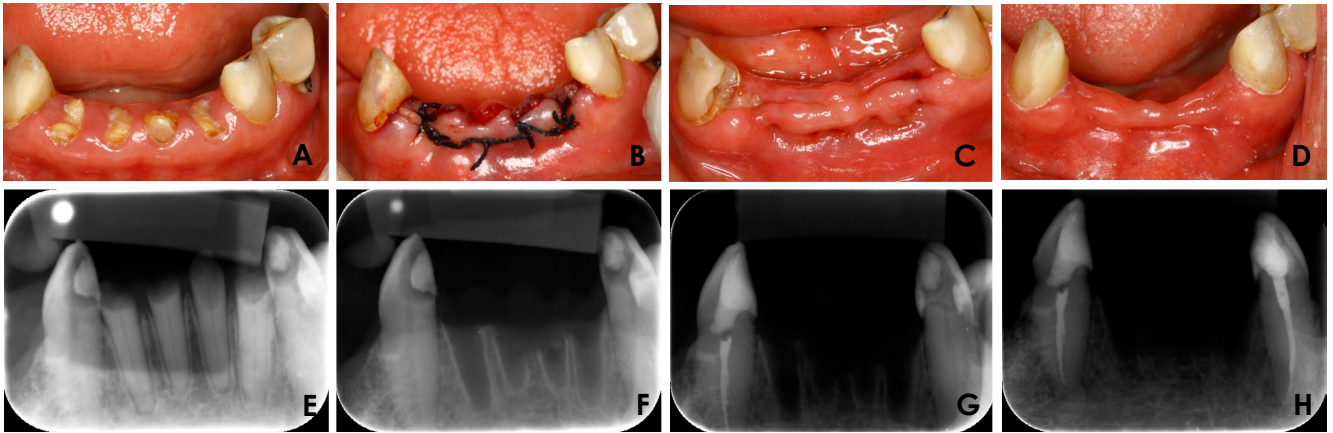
Clinical photographs. A. Preoperative. B. Immediately after the extraction of the 4 residual roots with subsequent alveoloplasty and occlusive suturing. C. Advanced process of primary intention healing at 7 days postoperatively. D. Complete soft tissue repair 30 days after the surgical procedure without evidence of any area of bone exposure. E. Preoperative digital periapical radiographs. F. Immediately after dental extraction. G. Two months after dental extraction. H. Twelve months after dental extraction. All postoperative images were analyzed to evaluate the average of bone formation.
